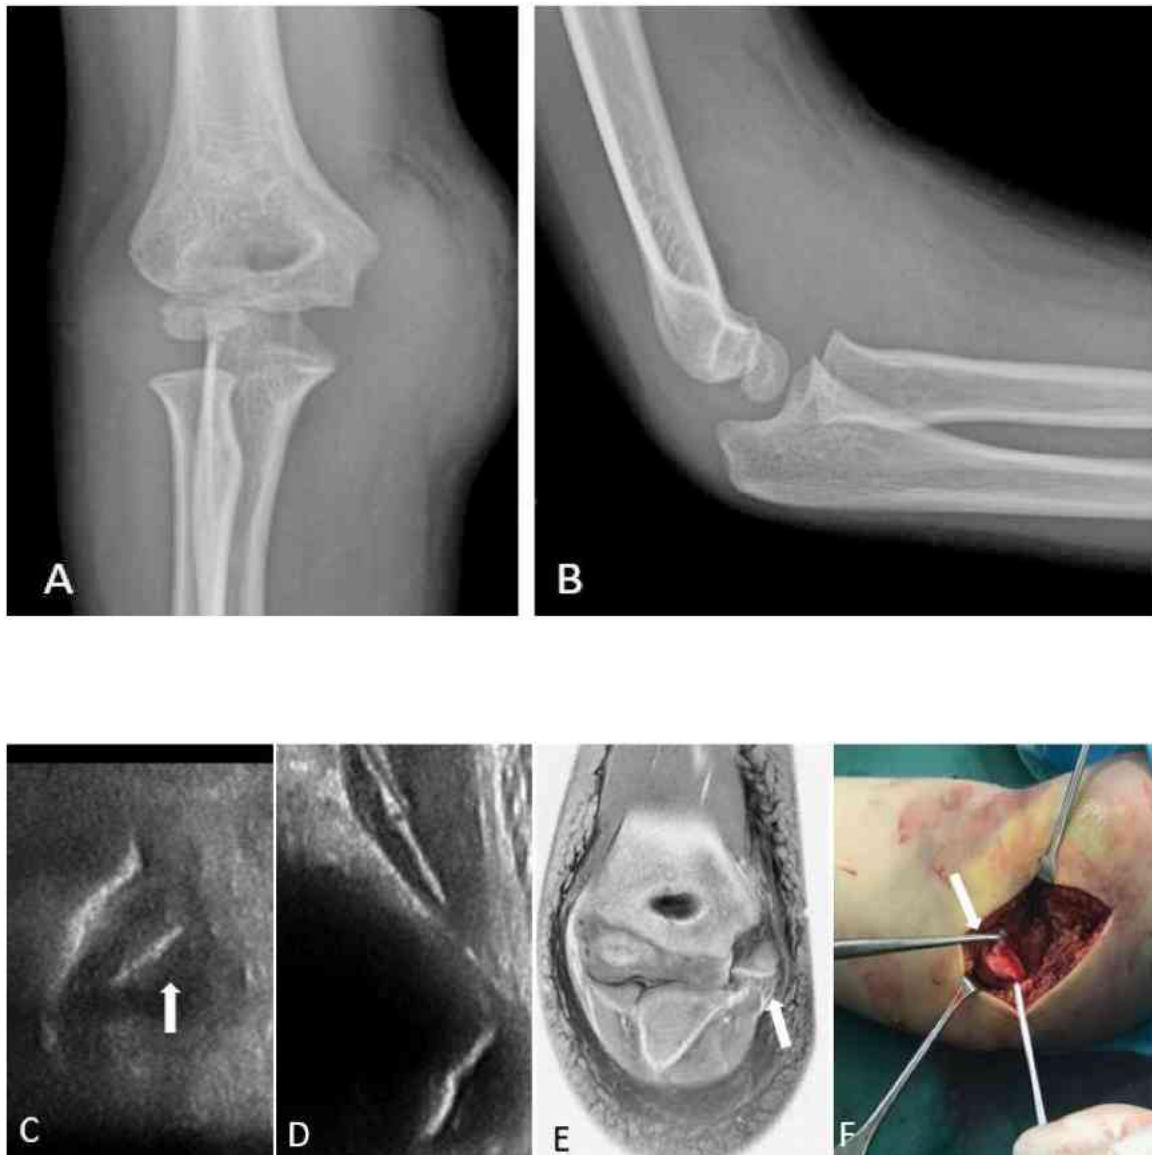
Displaced medial epicondylar fracture without X-ray abnormality
